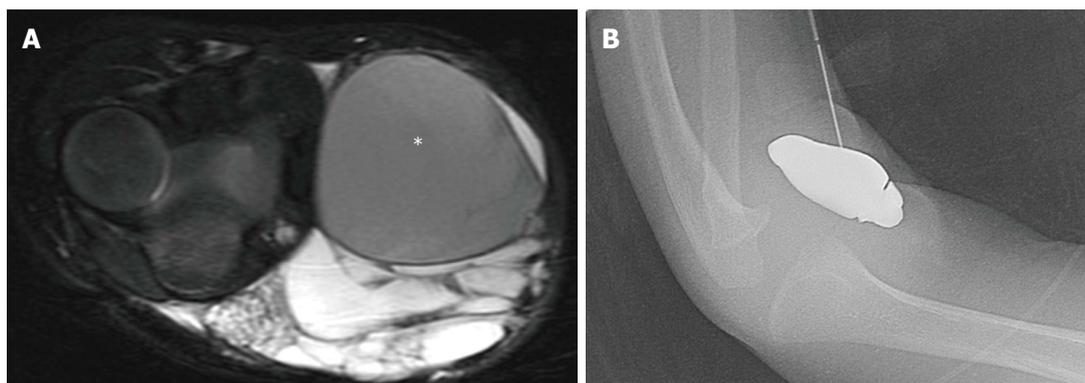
Macrocystic lymphatic malformation with hemorrhage. Axial fat suppressed T2 weighted magnetic resonance image of the elbow (A) demonstrates a predominantly hyperintense malformation with hypointense hemorrhage in a loculation (asterisk). Direct access to the malformation is obtained with a 22-gauge needle for sclerosis (B), subsequently performed with doxycycline.
